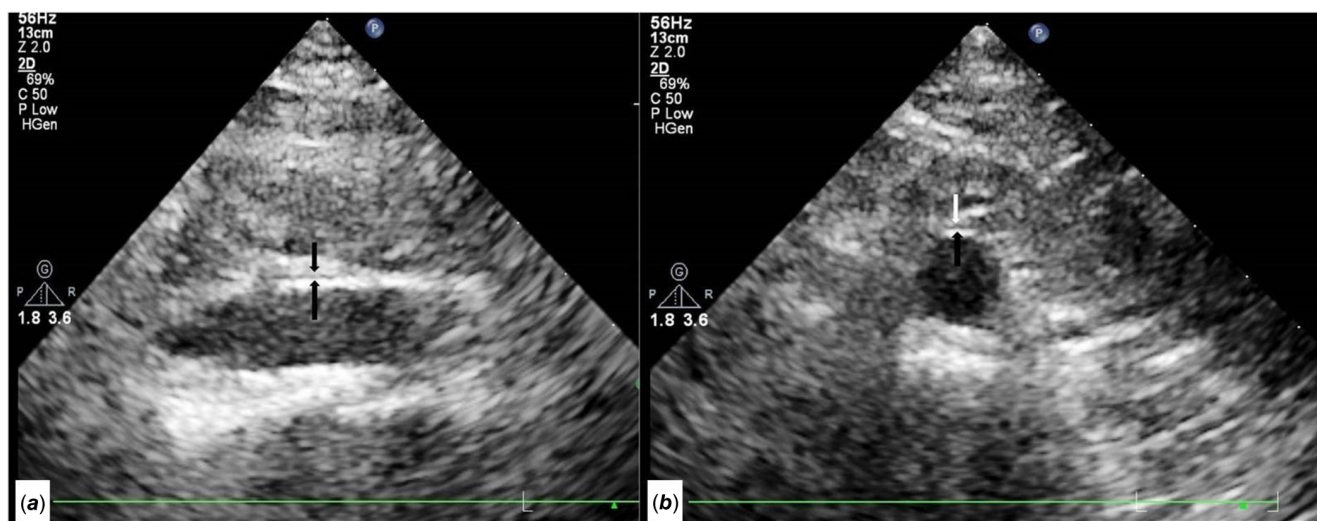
(a) Longitudinal (sagittal) and (b) transverse sections of periaortic adipose tissue and adventitia views on transthoracic echocardiography.
